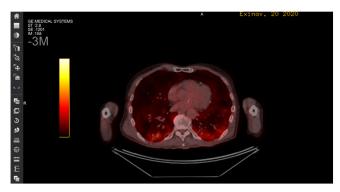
Positron emission tomography (PET-SCAN): Highlighted a consistent fixation of the FDG, at the level of the lower lobes, and the presence of metabolically active pulmonary infiltrates (FDG SUV max: 6.7 g/ml) mainly in the posterior but also at the tops next to lesions in a ground glass as well as of the pleura. No malign lesions identified.
